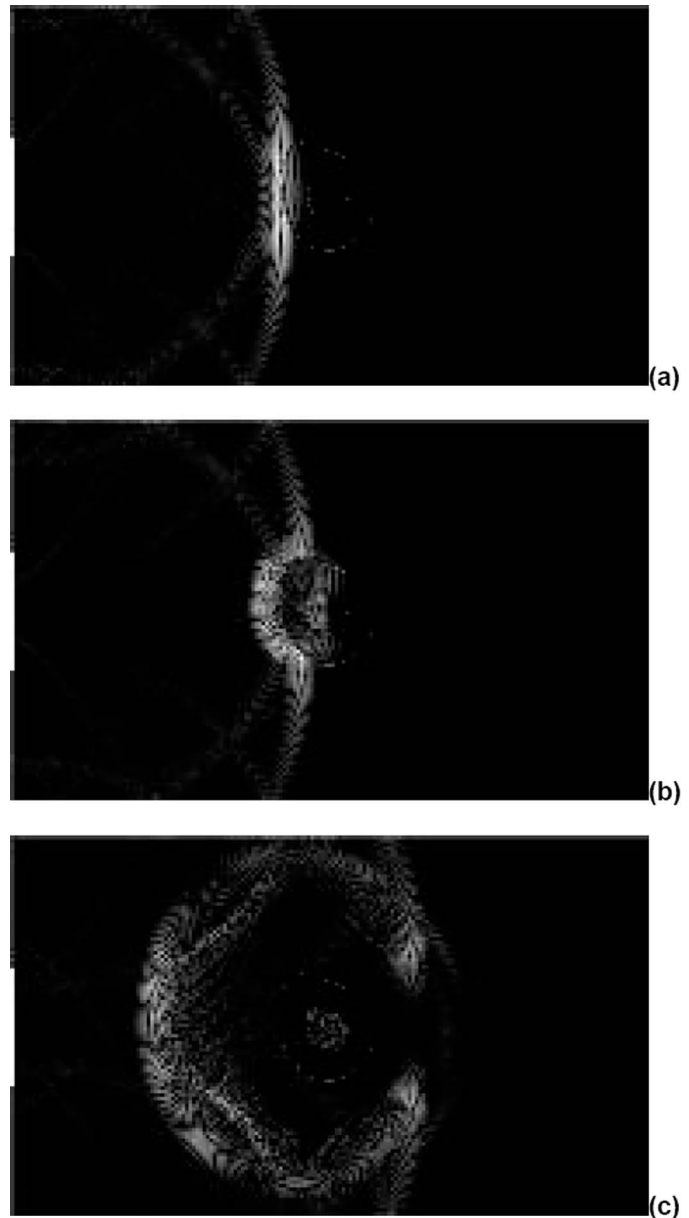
The ultrasound wave propagating through the radius cross section shown in Fig. 5, showing, from top to bottom, snapshots of the displacement magnitude at times = (a) 21.3 μ s; (b) 22.8 μ s; and (c) 31.3 μ s.
